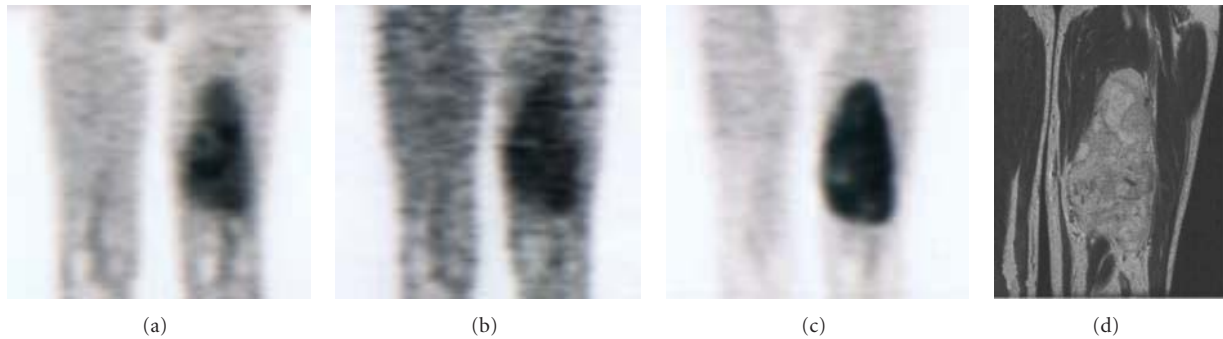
A 60-year-old male with neurofibroma in the left femur. ^{18}F -FDG (SUV = 3.49) (a), ^{18}F -FAMT (SUV = 1.40) (b), and ^{11}C -choline (SUV = 5.10) (c) showed clear tracer uptake in the tumor of the left femur, which corresponded to the area that was enhanced on MRI image (d).
